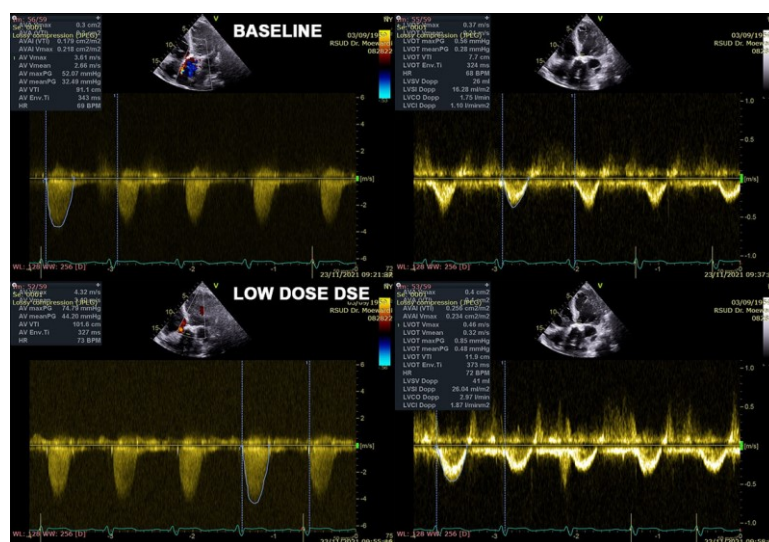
Comparison of echocardiographic results before and after low-dose dobutamine infusion.
